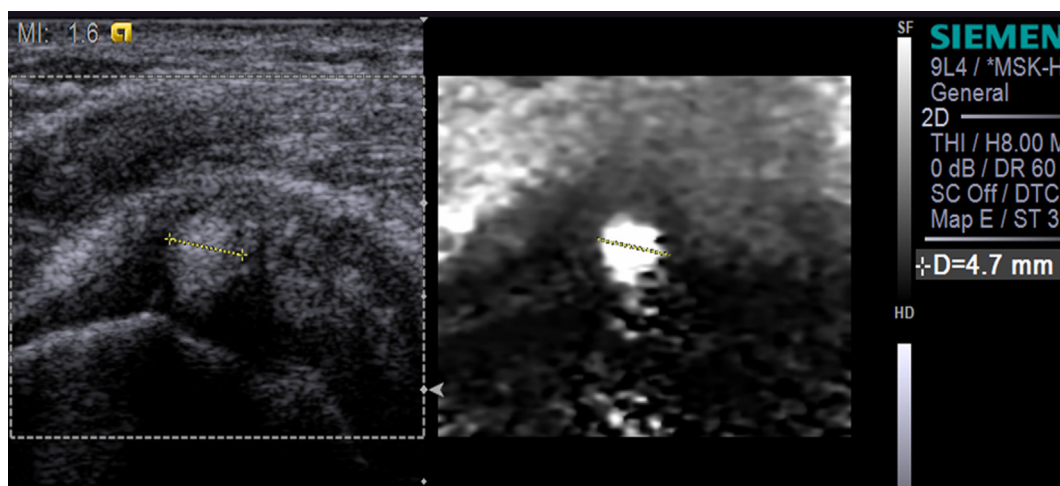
Imaging studies from a 52-year-old woman who complained of severe right shoulder pain for 8 months. Gray-scale ultrasound (US) showed echogenic nodular type calcific tendinosis (dotted line), and elastography exhibited a bright pattern (dotted line). This patient received US-guided aspiration and had pain relief.
